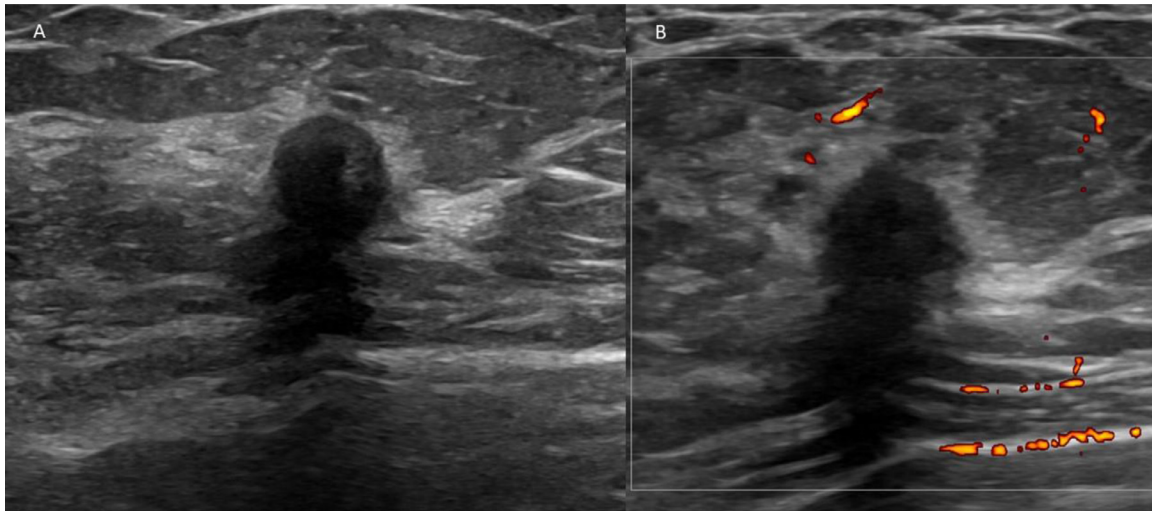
Grayscale (A) and power Doppler (B) images of the right breast mass from MRI-directed ultrasound demonstrate a suspicious round avascular mass with indistinct margins and posterior shadowing. Ultrasound biopsy was recommended and performed.
